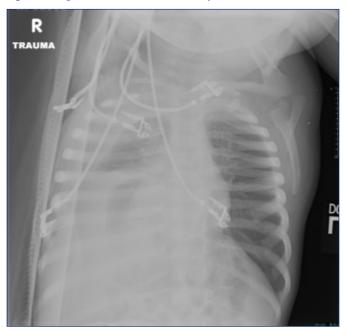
Right lateral decubitus chest X-ray
